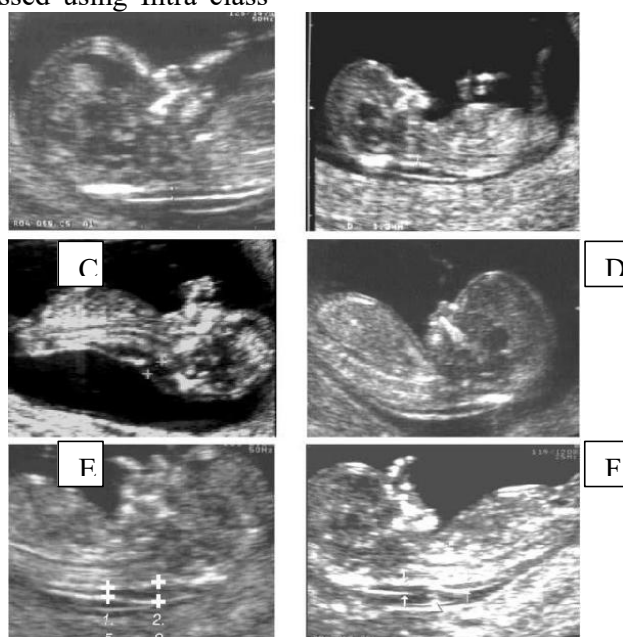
Sonogram of a 12 weeks fetus (a-f). Good fetal sagittal section (A-F), nuchal membrane separate from the amniotic membrane (A-F), fetal neck hyper-extended (B, C, E), and cursors placed at the fluid-membrane interface (A, E, F).
